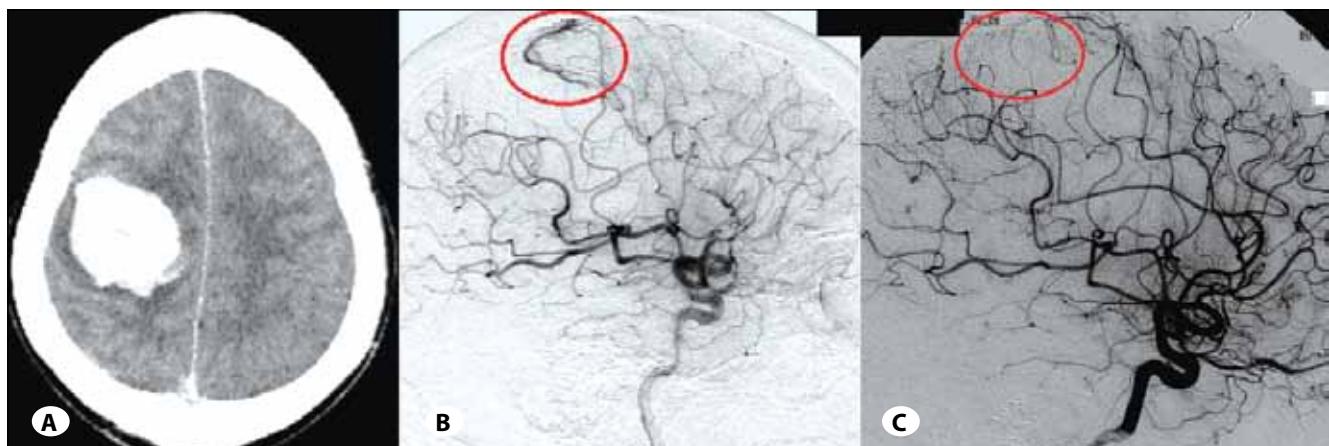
A) Brain computed tomography revealing an intracerebral hemorrhage in the right frontal-parietal lobe. B) Right frontoparietal AVM confirmed by cerebral angiography. C) No arteriovenous malformation is identified on the second angiography performed on day 19 of the hospitalization.
